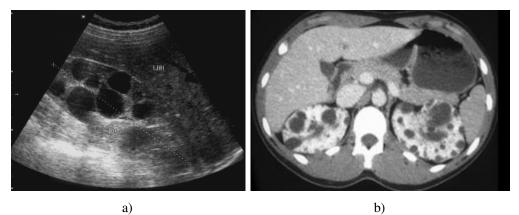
Ultrasound and CT exams:
